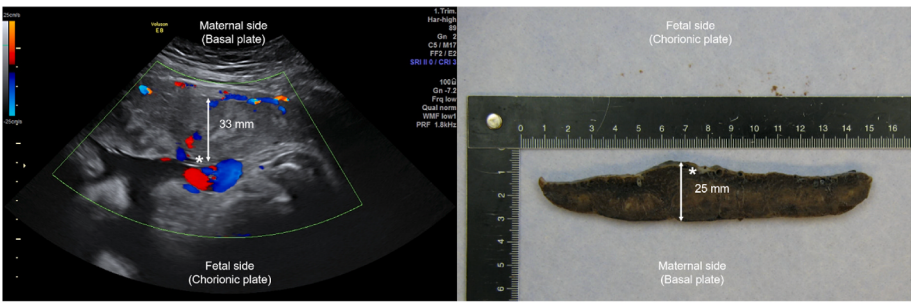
Placental thickness measured via ultrasonography vs in the delivered placenta. Left: Placental thickness of 33 mm measured via ultrasonography at 37 + 3 weeks gestational age (1 day before delivery per cesarean section). Right: Placental thickness of 25 mm measured in the delivered placenta at 37 + 4 weeks gestational age (day of the delivery per cesarean section). * Marks umbilical cord insertion.
